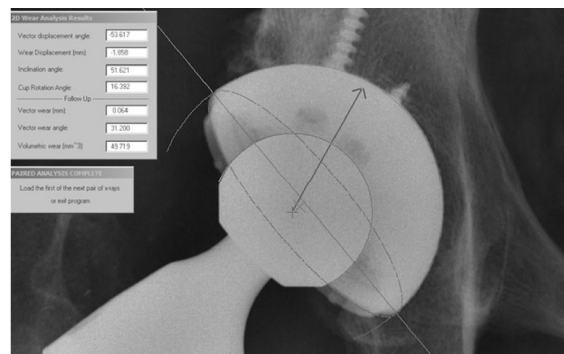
The Martell method of linear wear measurement shown on this radiograph [23].
